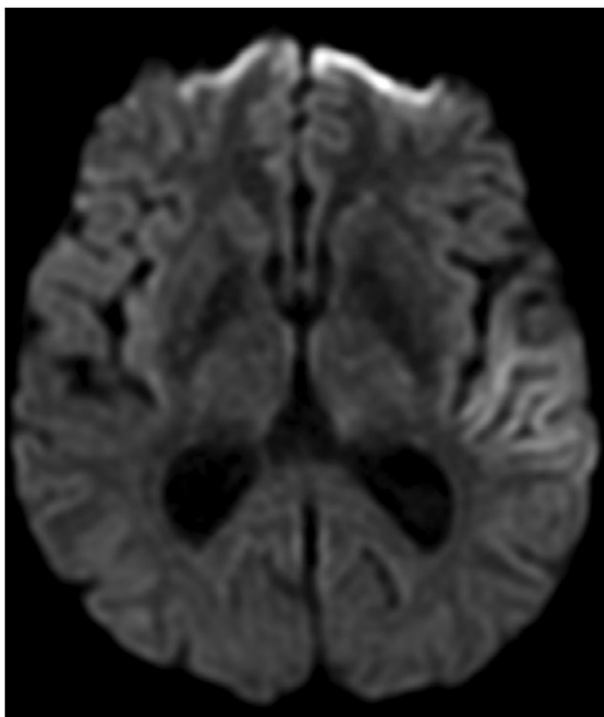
Axial DWI in post ictal state showing increased cortical sign in the upper left temporal lobe confirmed on the ADC map (not shown) to be diffusion restriction.
